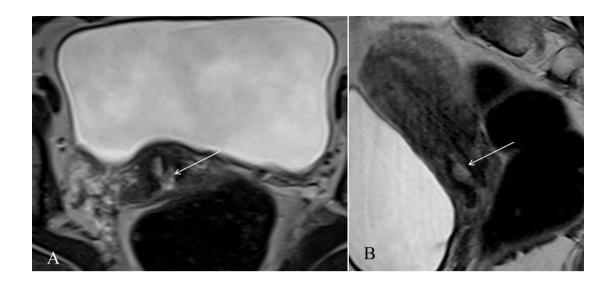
(A) Axial and (B) Sagittal T2 weighted MRI showing hyperintense lesion confined to cervix (white arrow), staged as IB.
